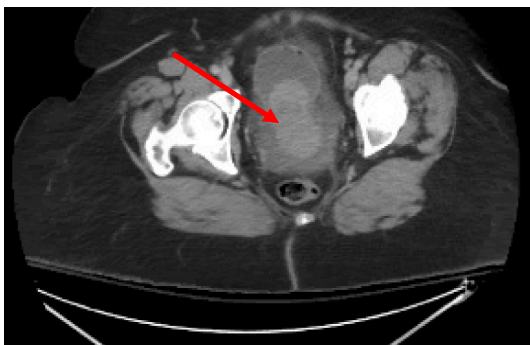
CT of the Abdomen and Pelvis with contrast demonstrating a hyperdense lesion in the bladder extending through the posterior wall.
